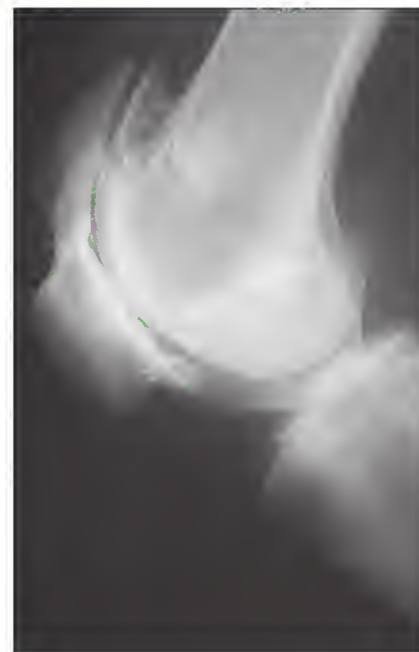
Knee radiograph showing hypertrophic osteoarthritis. Note the prominent patellofemoral involvement typical of osteoarthritis with calcium pyrophosphate deposition.
